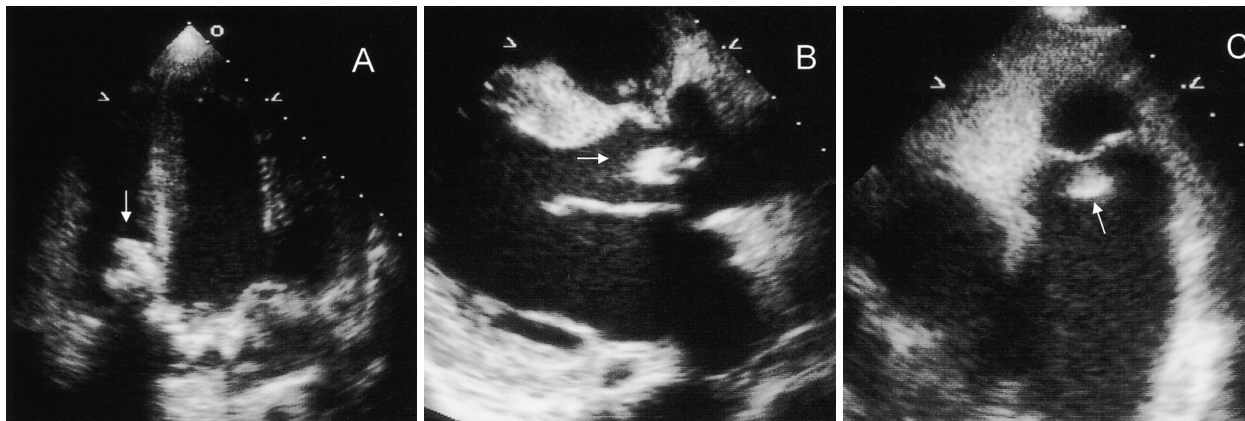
Transthoracic echocardiograms demonstrating vegetations (arrows) on the tricuspid valve (A) aortic valve (B) and pulmonary valve (C)
